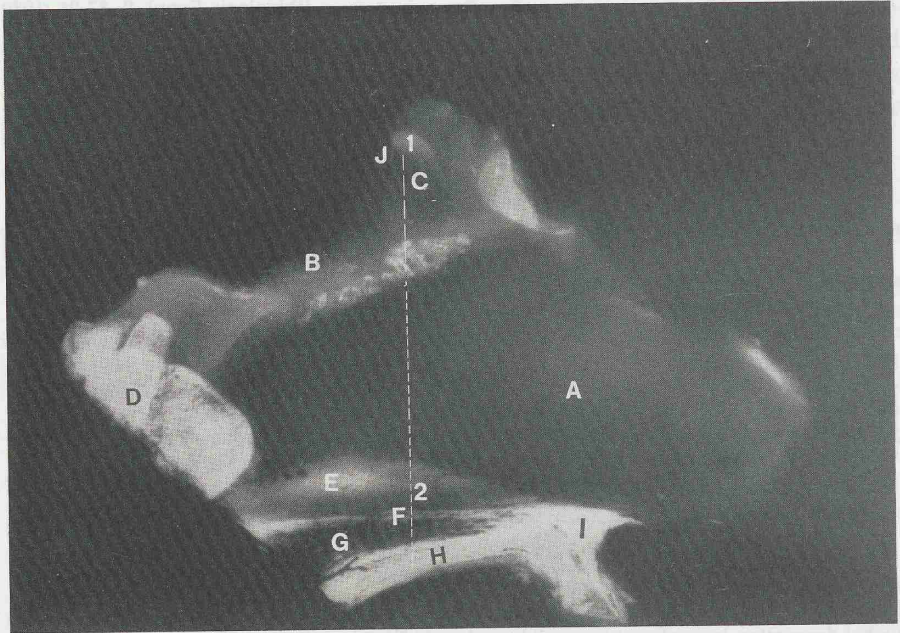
Lateral X-ray picture of nasal septum, neonate.
